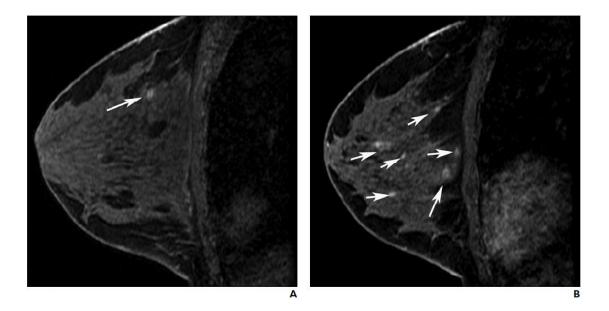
[27]: Focus and foci of enhancement. MRI images from 49 year old woman with palpable abnormality in right breast, radiologic findings suggested fibrocystic disease. Image A (left) shows dynamic contrast-enhanced image of left breast with subcentimeter focus (arrow) of delayed enhancement in upper aspect of right breast. Image B (right) shows multiple foci of enhancement (arrows) throughout right breast. All foci were stable for at least 1.5 years and considered benign.
